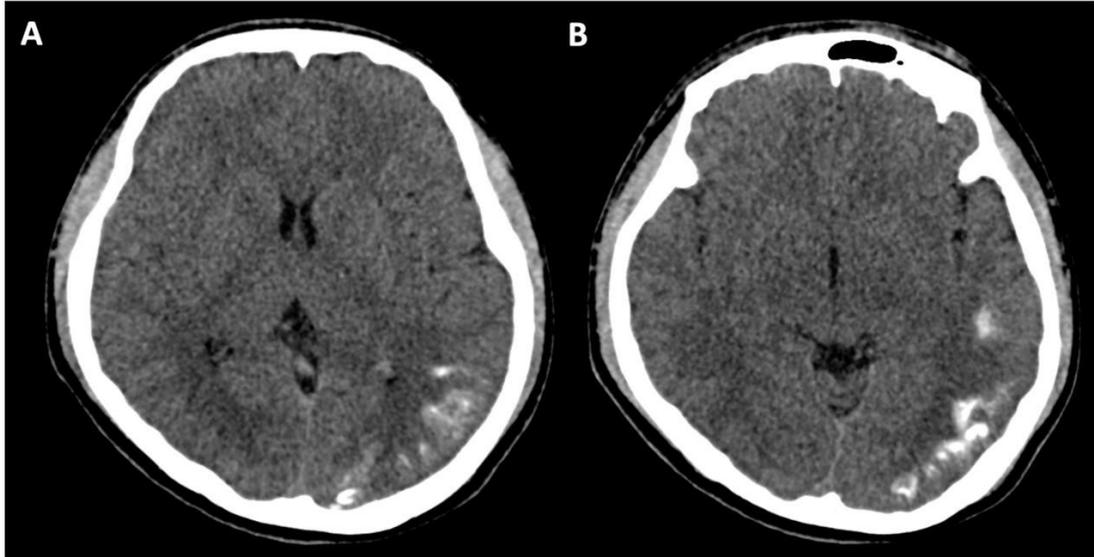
Non-contrast CT Brain at the level of (A) lateral ventricles and (B) midbrain showing left parietal cortical and subcortical calcification with a 'tram-track' appearance.
